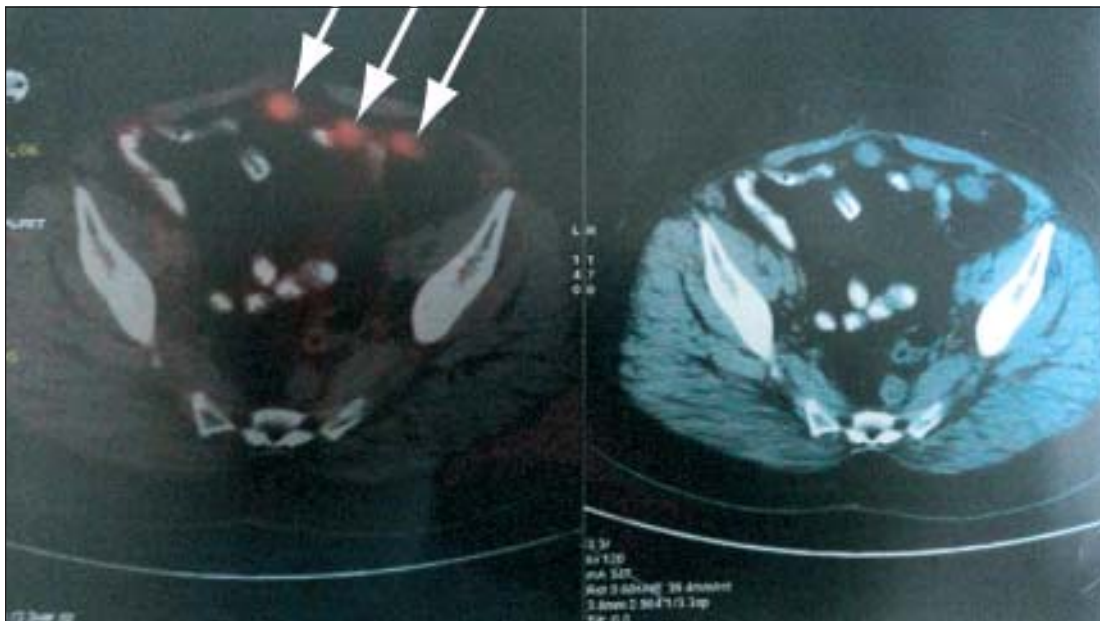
Marked areas show increased FDG uptake in a PET/CT Scan suggesting metastatic deposits
